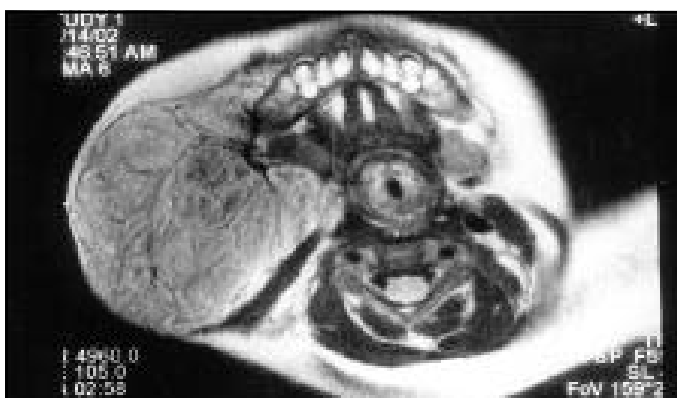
Magnetic resonance imaging scan depicting the huge mass with an iso to high T2 signal intensity image. Note encroachment of the mass into the parapharyngeal space.
